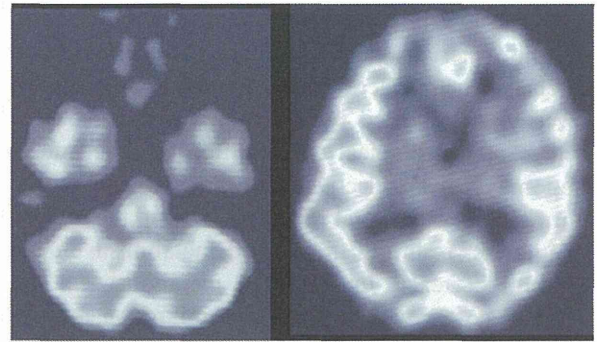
Single-photon emission computed tomography (SPECT) images of a 58-year-old woman with symptomatic occlusion of the left middle cerebral artery (MCA). While blood flow asymmetry in the cerebellar hemisphere is not observed, blood flow in the left MCA territory is reduced when compared with blood flow in the right MCA territory. This patient developed stroke recurrence in the left MCA territory 5 months after entry into the study.
